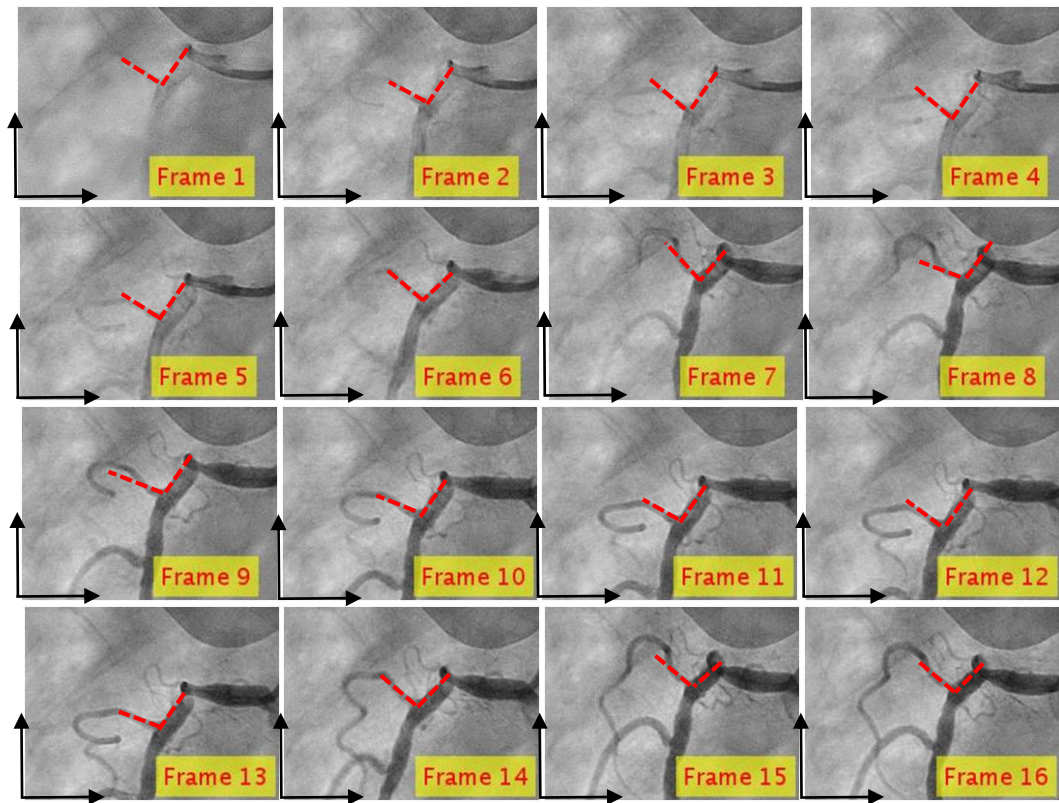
X-ray images showing position and angle variation of a vessel branch for six different images captured at 15fps over one cardiac cycle, with respect to the origin shown in black arrow, the angle of branch (shown in red dotted lines) and the location of branch (intersection of red dotted lines is not changing much)
